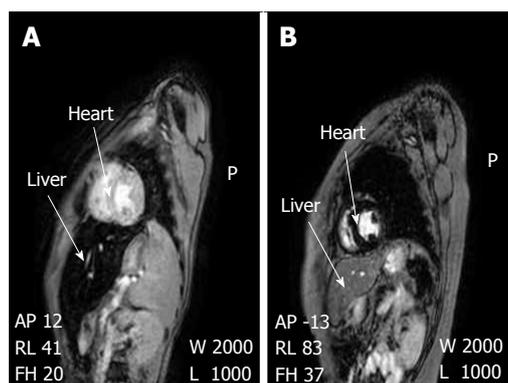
Non homogeneous iron distribution among the organs of iron loaded thalassaemia patients. Differential iron loading of the heart and liver of two iron loaded thalassaemia patients using MRI and T2* estimation. A: Heavy haemosiderosis of the liver [T2* = 1.2 ms (normal T2* \geq 6.3)] and normal T2* of the heart (T2* = 20.6). The top arrow shows the interventricular septum of the heart of the patient with no iron deposition (normal) where the bottom arrow shows the heavy iron loading within the liver parenchyma, demonstrated as low signal intensity (dark); B: Heavy haemosiderosis of the heart (T2* = 6.32 ms) and normal T2* of the liver (T2* = 19.2 ms). The top arrow shows the abnormal iron deposition in the interventricular septum of the heart of the patient, which is shown with low signal intensity (dark). The bottom arrow shows the liver of the patient with no iron deposition (normal). Adapted from ref. [14]. MRI: Magnetic resonance imaging.
